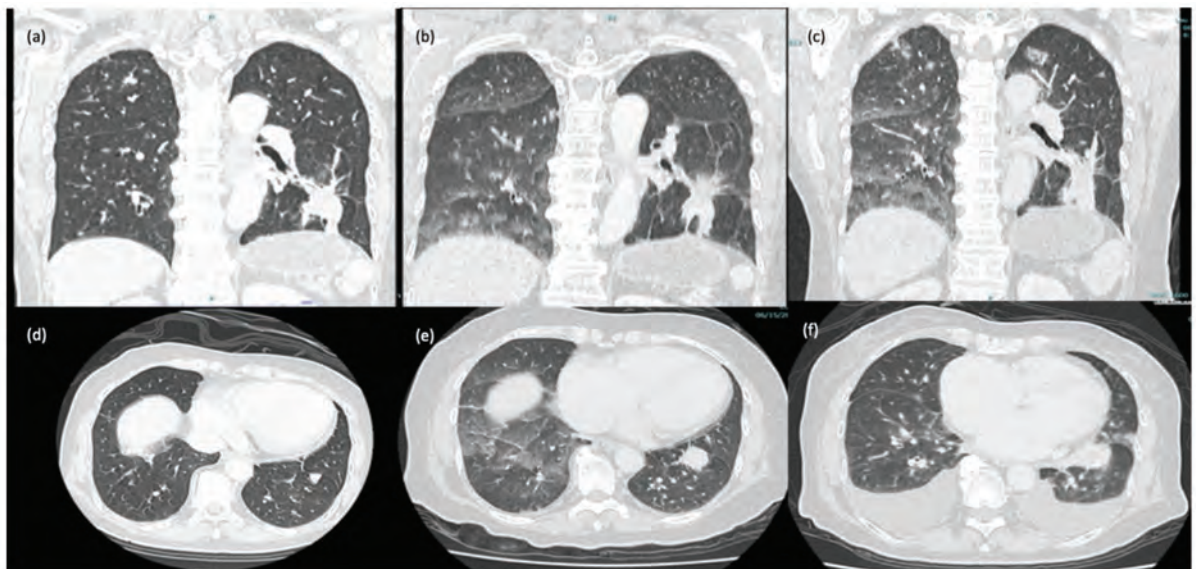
(a),(d) CT images during first generation TKI treatment. (b),(e) CT images showing disease progression after first generation TKI. (c),(f) CT images showing larger lung nodule with presence of new pleural effusions, confirming disease progression while on osimertinib
